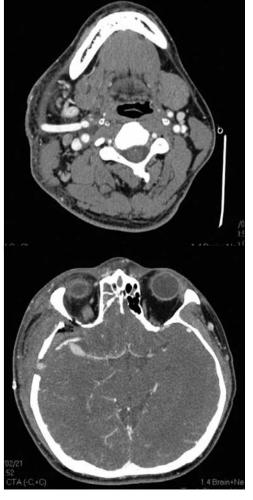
Brain CT angiogram showed good patency of the graft after the EC-IC bypass operation with interposition of saphenous graft. Further intervention was suggested. We decided to perform angioplasty and stenting to help him. Heparin was given before the stenting. A 5 mm x 30 mm stent (Cordis, Bridgewater, New Jersey, USA) was deployed to cover the stenosis. We then used an inflated balloon (5 mm x 15 mm, Cordis, Bridgewater, New Jersey, USA) for post-dilation (Figure
